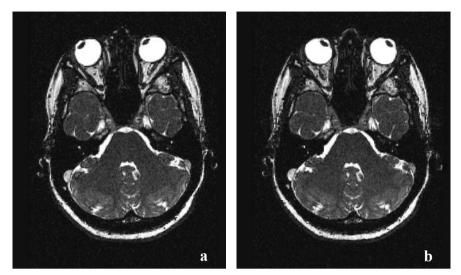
Axial MRI-slices from the 4D-imaging series for the human eye movement, a: start, eyes oriented to the left, b: end, eyes oriented to the right
